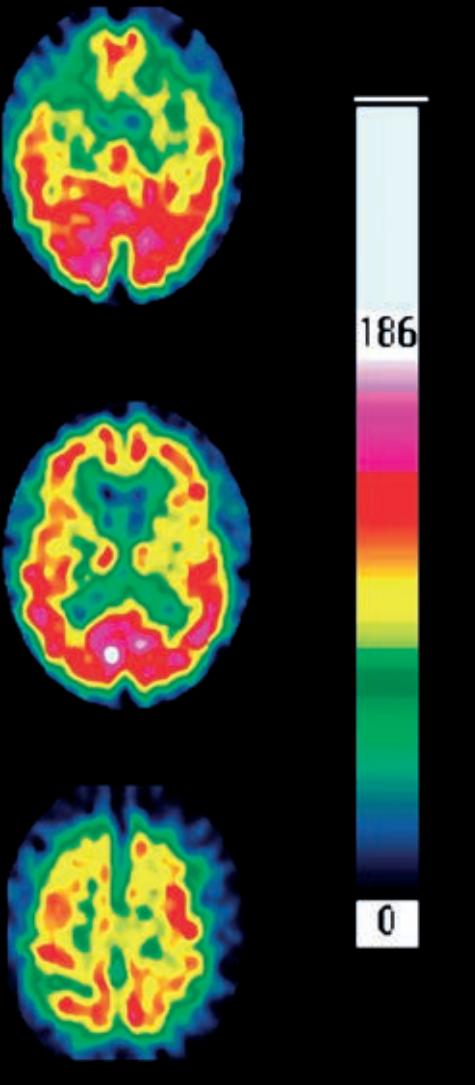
Coloured single photon emission computed tomography (SPECT) scans of axial sections through the brain of a patient with Huntington's disease
